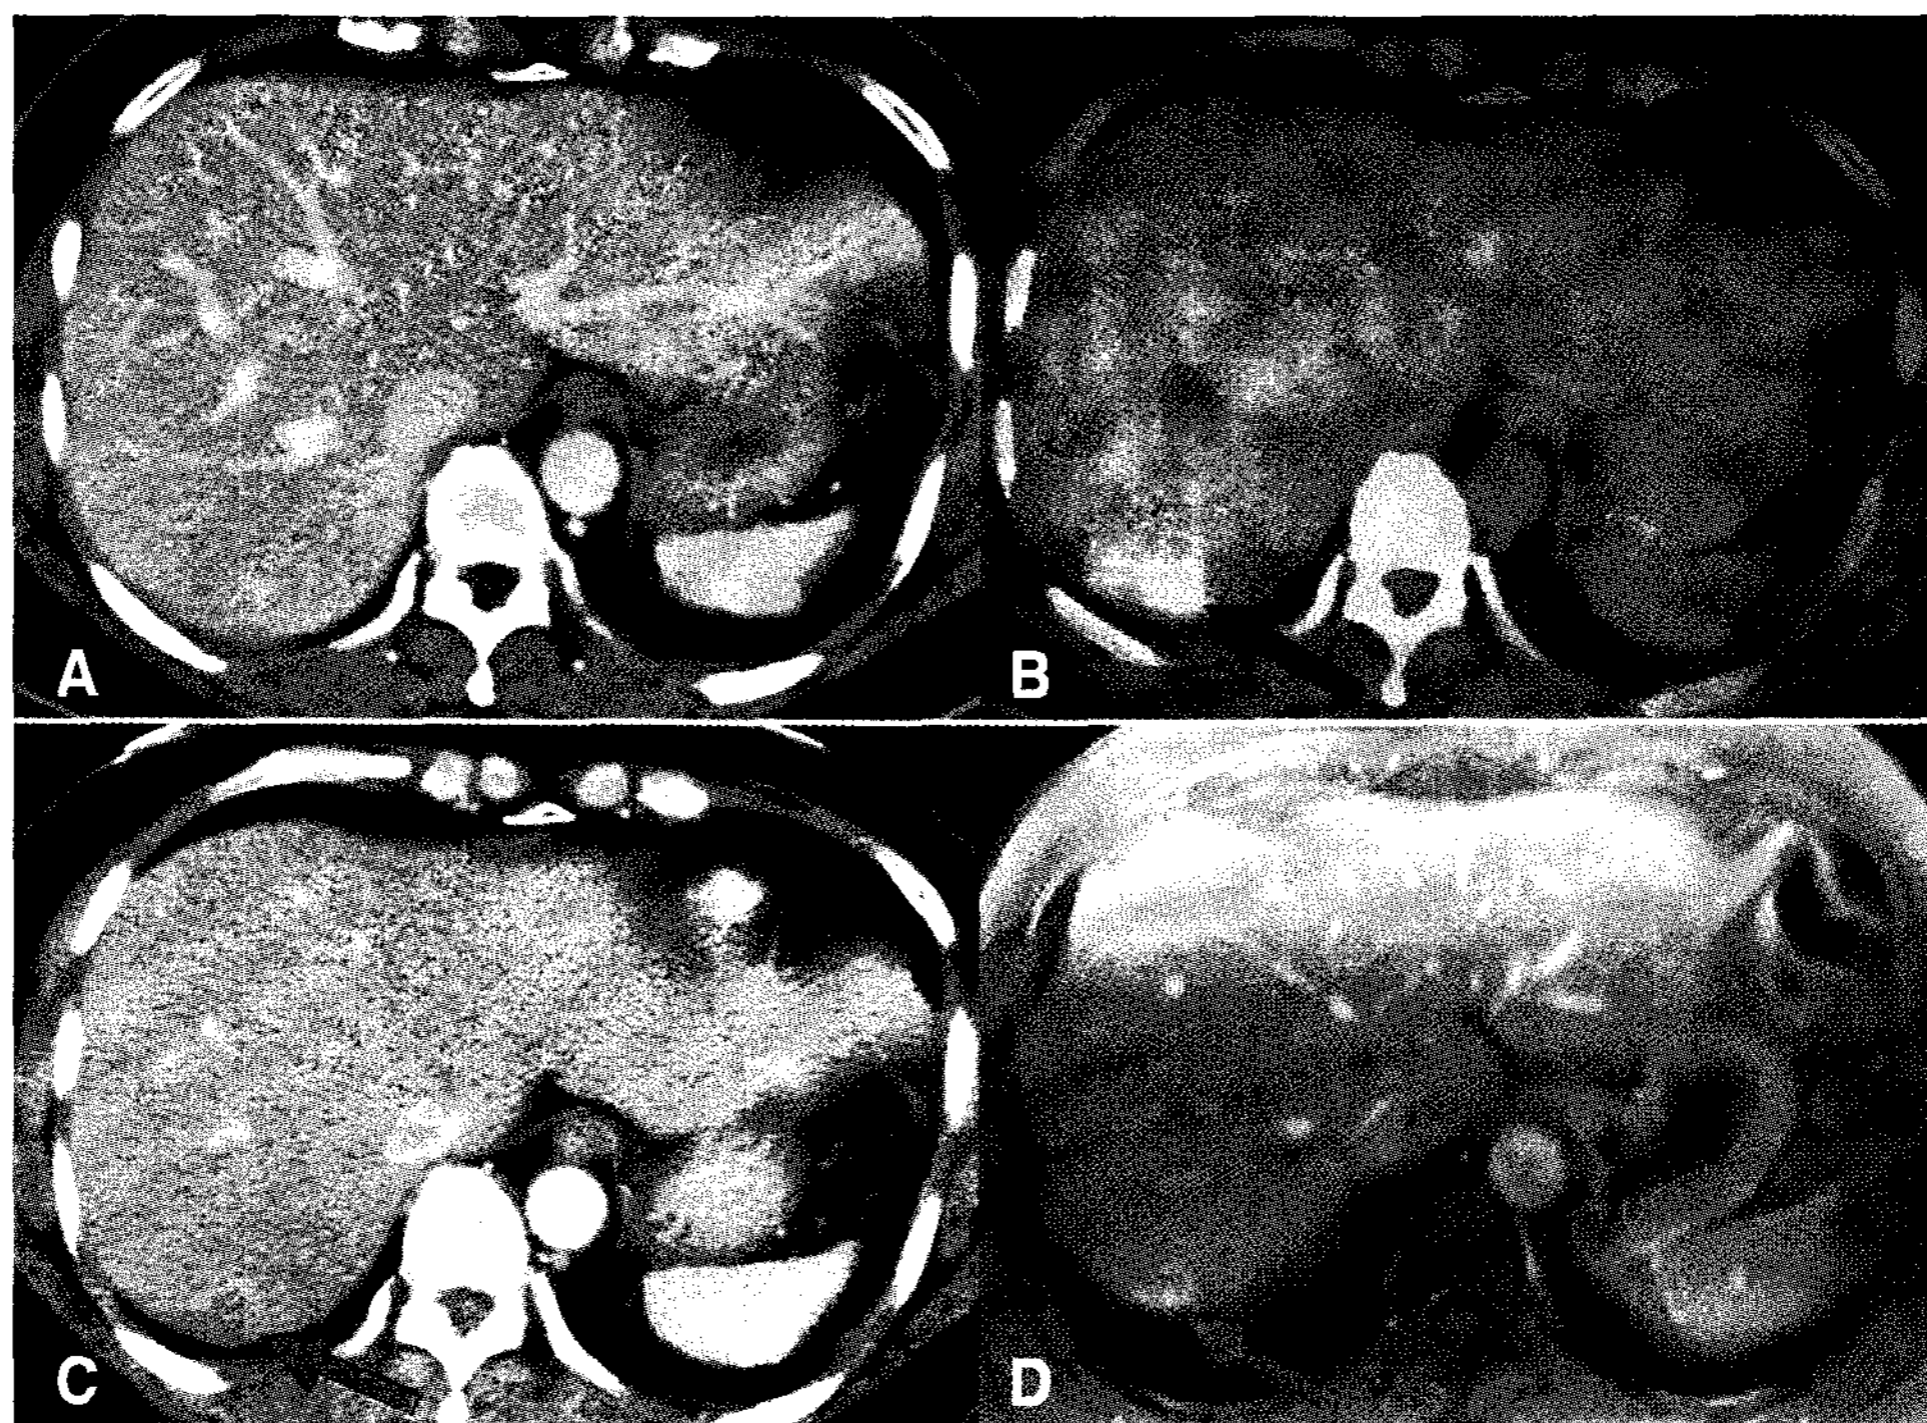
A 52 year old patient received operation and chemotherapy for papillary serous cystadenocarcinoma of the ovaries. Enhanced CT exam done 16 months after the termination of chemotherapy (A) shows no perceptible abnormality, and CA 125 level was normal at 18.13 IU/mL. However, PET/CT exam performed 3 weeks later (B, arrow) demonstrates focal FDG uptake in posterior margin of segment 7 of the liver. On follow-up CT exam done 3 months later (C, arrow), about 2.1 cm sized hypodense nodule is seen in the same area of right hepatic lobe. MRI exam 4 months after the PET/CT (D, arrow) also shows enhancing nodule, and CA 125 was elevated at 90.69 IU/mL.
